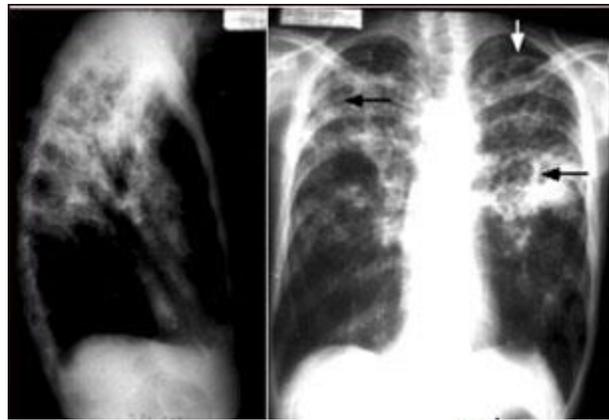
X-Ray of patient with progressive pulmonary tuberculosis (Medline Plus, 2012)
